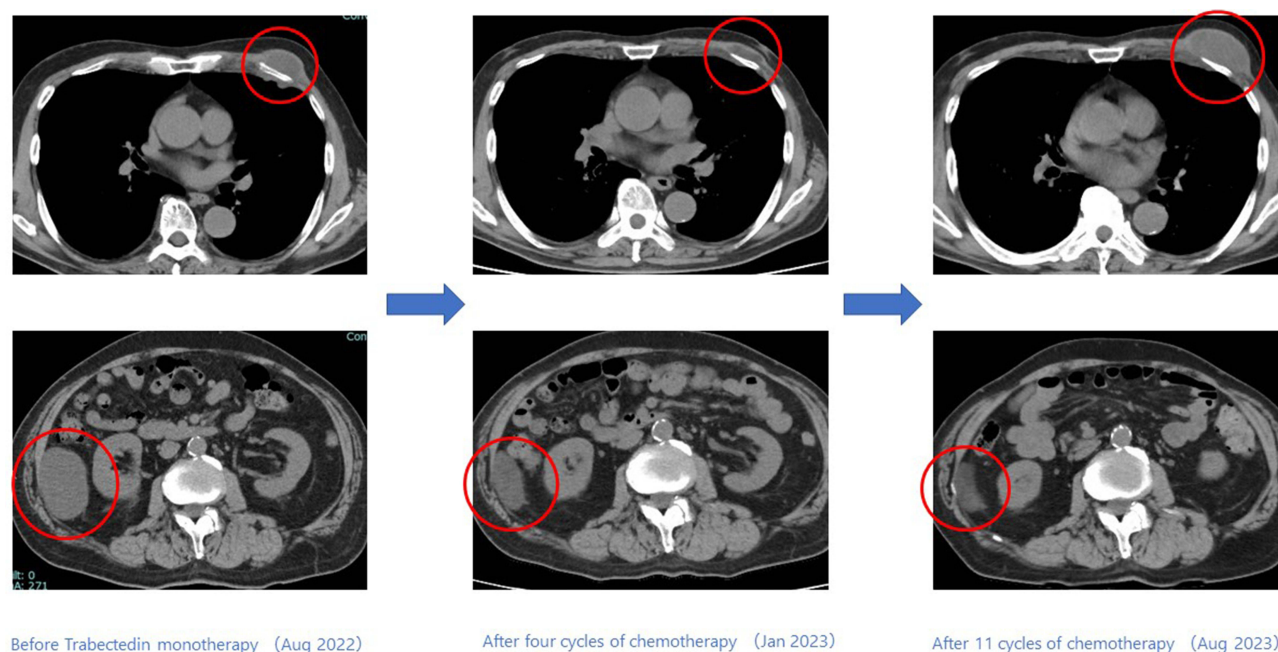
Changes in imaging of Case 4 patient before and after trabectedin administration (Chest and abdominal CT) Metastatic site of left chest wall and retroperitoneal metastatic lesion showed a partial response after four cycles of trabectedin monotherapy compared to the findings of pre-treatment. After 11 cycles of chemotherapy, CT image showed that while the retroperitoneal lesions had further shrunk, the chest wall lesions had exacerbated again, leading to an overall assessment to be disease progression.
